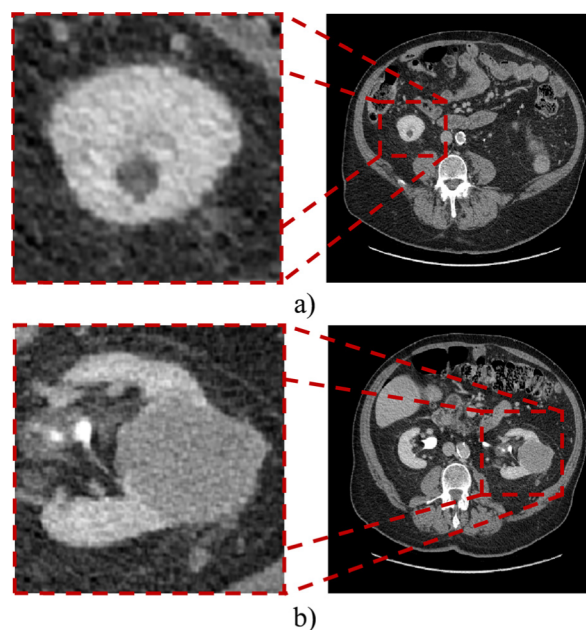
An example of a) benign renal cyst b) solid renal mass on CECT images. The 2D CT images are visualized in the standard abdominal window and level set of 400 and 50, respectively.
